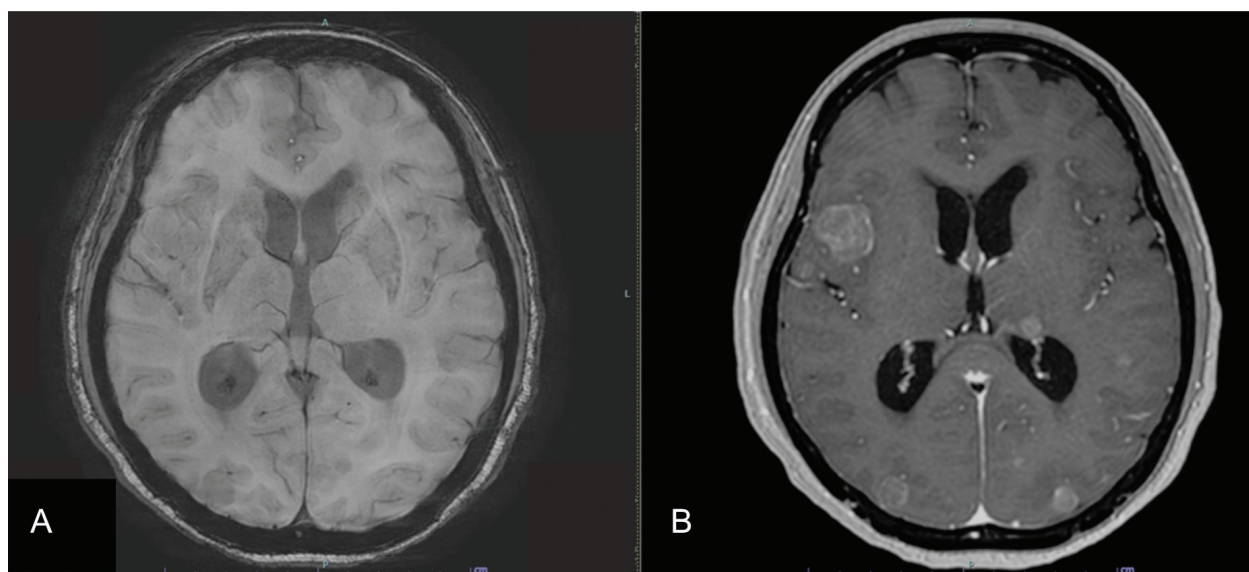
MR image “positive on SWI and positive on THRIVE technique”. Axial MRI scan of a 39-year-old female with a history of breast cancer and a newly diagnosed brain metastasis in the right frontoparietal region. A. Susceptibility-weighted imaging (SWI) demonstrates a blooming-signal void area at the right frontoparietal region (the long black arrow). Massive vasogenic brain edema in both cerebral hemispheres on the SWI were also detected. (the short black arrow) B. Post-contrast T1-weighted MRI sequence (THRIVE) demonstrates an abnormal, irregular, rim-enhancing lesion at the same area of positive SWI (the long white arrow). Massive vasogenic brain edema in both cerebral hemispheres on the THRIVE technique were also detected. (the short white arrow).
